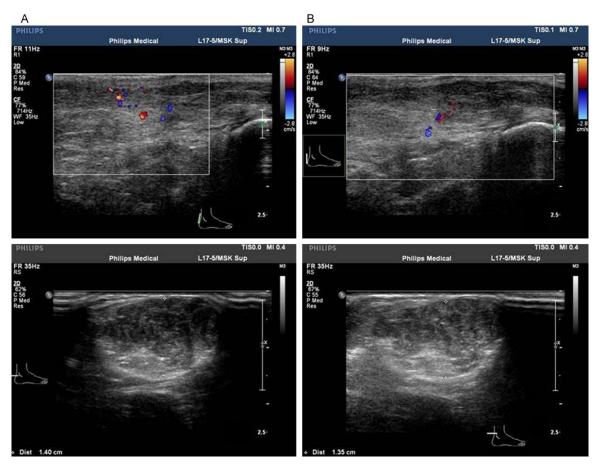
Ultrasound (US) imaging features of the patient at different points in time: the pictures above show blood flow in the Achilles tendon, while the corresponding pictures below display the degree of Achilles tendon swelling. A. US (Oct 28, 2014): The Achilles tendon appears to have diffuse swelling (especially in the middle and lower parts), the echo of the tendon fiber is reduced, and the texture is blurred. The thickest part of the tendon is 14 mm. The tendon has good continuity and an abundant blood supply. There is no obvious tendon calcification. The cortex at the end of the calcaneus is smooth, and there is no obvious effusion in the posterior capsule. B. US (Jan 25, 2015): Compared with previous (images from Oct 28, 2014), the thickness of the Achilles tendon decreased, and the local blood flow also decreased.
